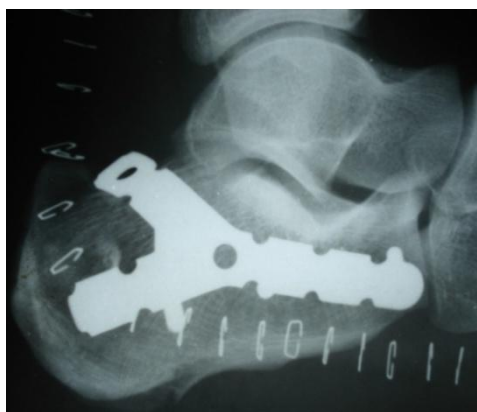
Post-op X-ray of calcaneal fracture
